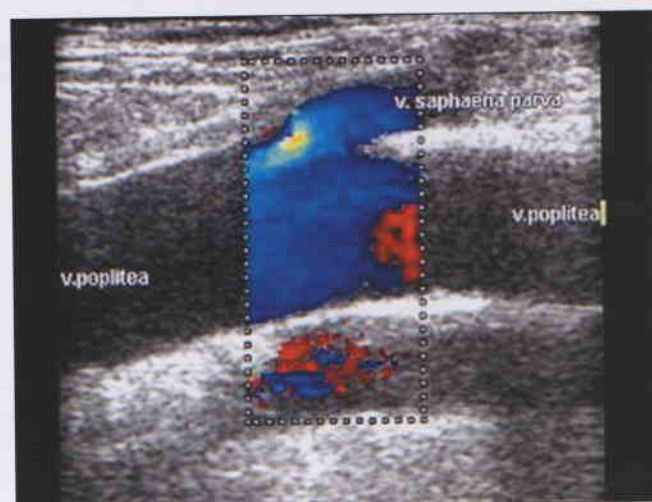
Colour duplex sonography of the sapheno-popliteal junction.
